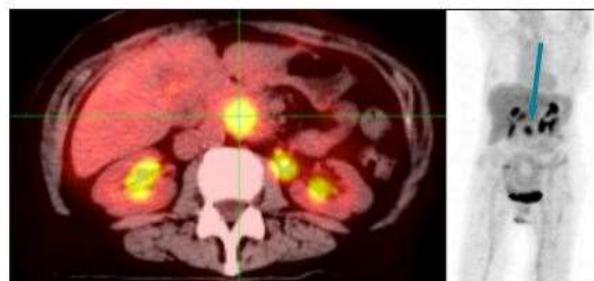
FDG-Onco-PET-CT vom 30.01.2019, Primärtumor im Pankreaskopf durch Fadenkreuz in 14a und blauen Pfeil in 14b markiert
